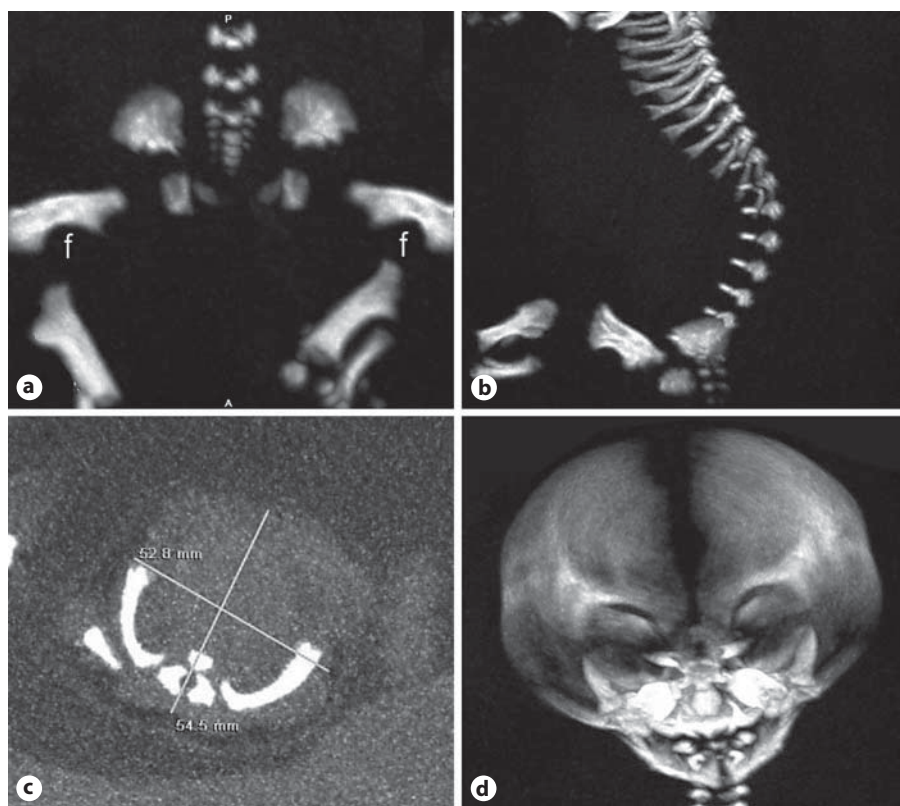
Case 6: thanatophoric dysplasia type I. 3D-CT reconstructions. a Telephone-receiver-like femurs, spinal and pelvic malformation. f = Femur. b Platyspondyly. c Narrow chest with short ribs. d Characteristic craniofacial appearance (brachycephaly and megalencephaly).
